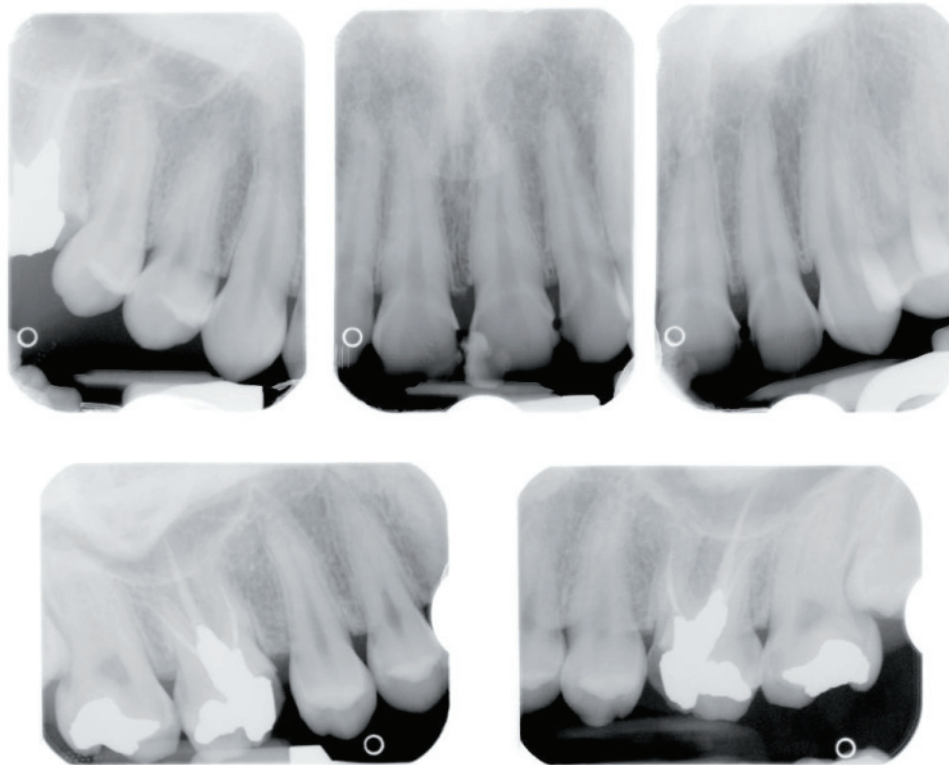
Radiographs showing enamel loss of maxillary anterior teeth, with normal periapical tissue.
